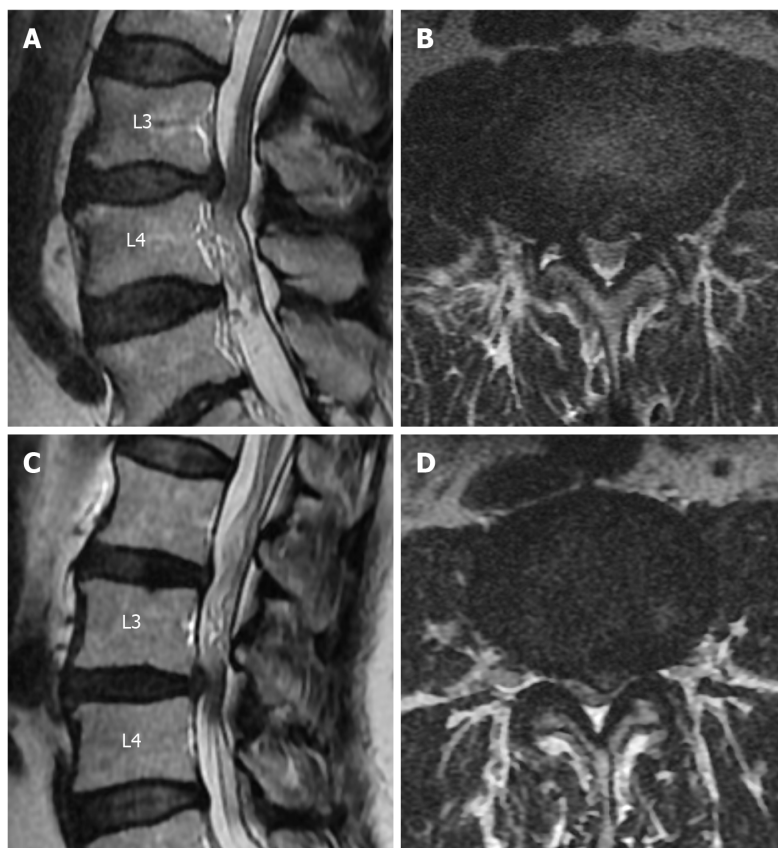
Seventy-one-year-old male patient with lumbar spondylosis. A: On the sagittal T2-weighted image, redundant nerve roots (arrows) secondary to the stenosis at L2-L3 level are shown at the inferior of stenosis level; B: On the axial T2-weighted image passing through L2-L3 intervertebral disc space level, marked stenosis due to ligamentum flavum and facet joint hypertrophy and disc herniation (cross-sectional area was 41.33 mm<sup>2</sup>) are shown.
